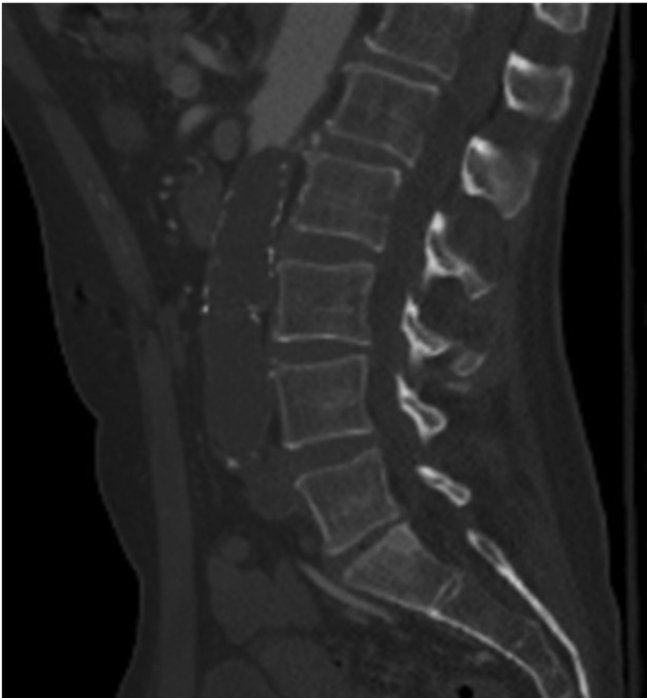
Initial computed tomography angiogram showing infrarenal descending aortic occlusion.
